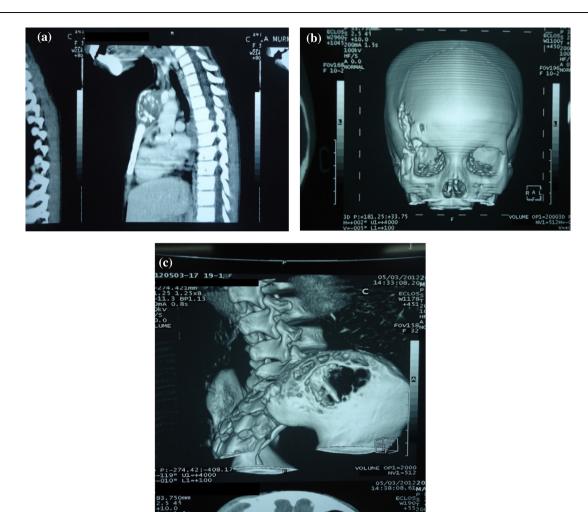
(a) Reconstructed CT images showing Gross destruction with osteolysis at the manubrium sternum with overlying soft tissue thickening. Destruction is more at the inner cortex with extension of soft tissue component at the superior mediastinum. (b) Reconstructed CT images showing small lytic area at the right side of frontal bone which extends to involve the zygomatic bone near superior orbital margin. (c) Reconstructed CT image showing multiple lytic lesions with conglomerations and irregular margin at right iliac blade.
